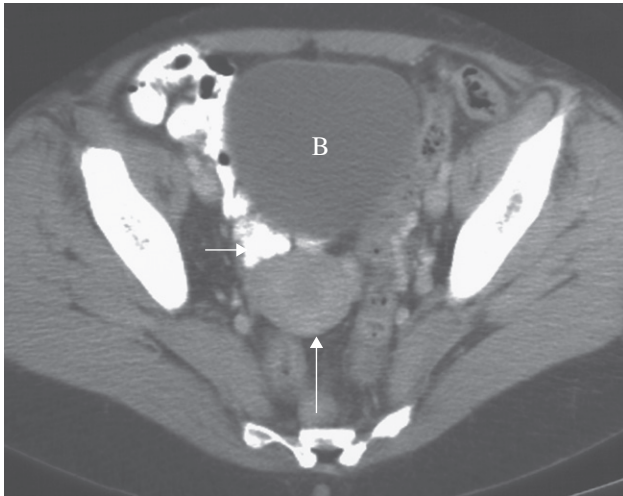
Normal uterus (long arrow) in a 49-year-old patient, on CT, following intravenous contrast enhancement. Note the oral contrast medium within loops of the small bowel (short arrow). B, bladder.
